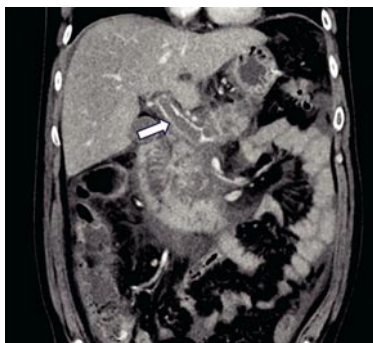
White arrow pointing at thrombus in portal vein on CT
